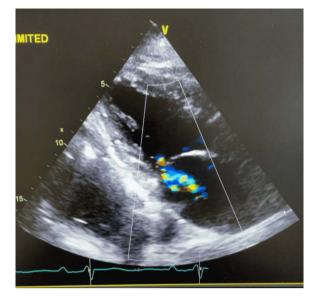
Echocardiogram in parasternal long axis view, with colour doppler (post-Percutaneous Mitral Clip Placement procedure), showing improved mitral regurgitation.
